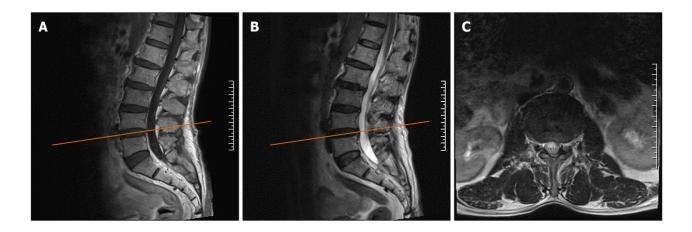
Plain magnetic resonance imaging of the lumbar before the operation. A: T1 sagittal image showing intervertebral disc bulging at the L4/5 level, which caused slight compression of the anterior edge of the dural sac but not to the extent that causes neurological symptoms; B: T2 sagittal image of the L4/5 level; C: The horizontal image correlated with the L4/5 intervertebral space, as indicated by the yellow scout line in the panel.
